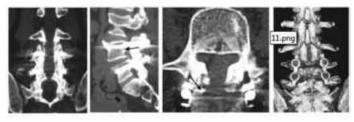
CT scan sections showing Lenke A fation mass with beta TCP and local bone graft. The arrows point to the continuous solid fation mass.
